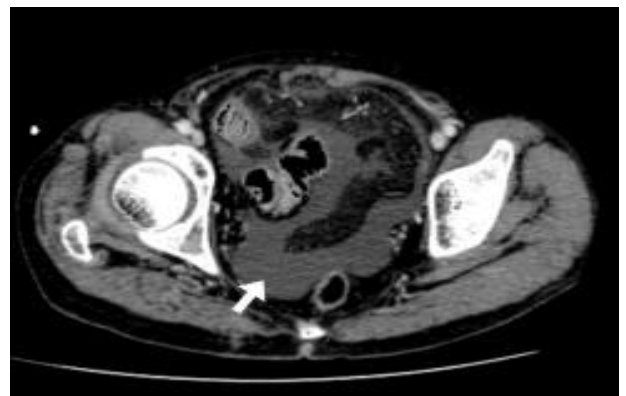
CT scan showing moderate ascites (white arrow) in the Douglas fossa.
